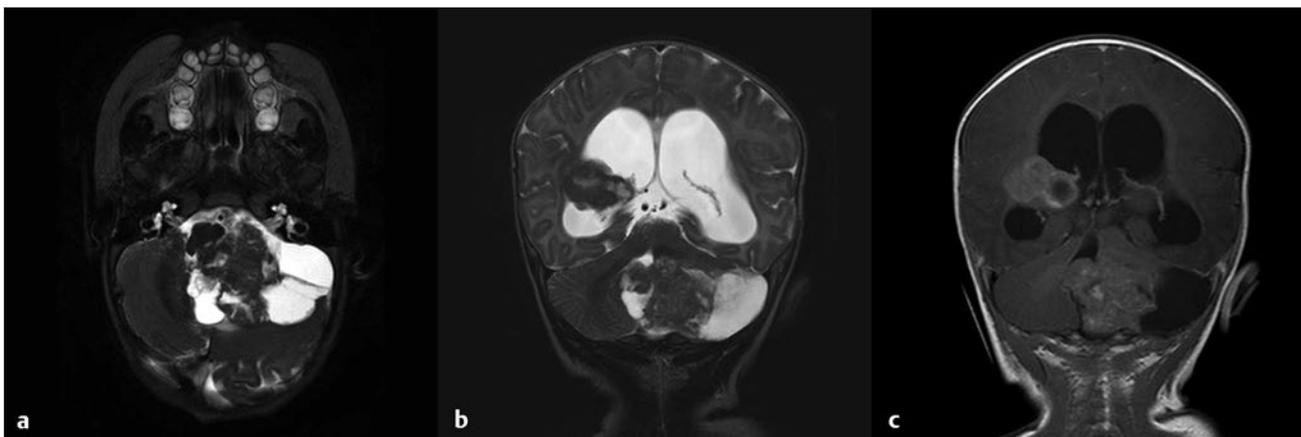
Magnetic resonance images of an atypical teratoid/rhabdoid tumor of the posterior fossa and right lateral ventricle. (a) T2-weighted axial image demonstrating a large mass with cystic component in the posterior fossa and mass effect on the brainstem. (b) T2-weighted and (c) T1-weighted coronal images with gadolinium demonstrating both the posterior fossa and the right lateral ventricle lesions, with obstructive hydrocephalus.
